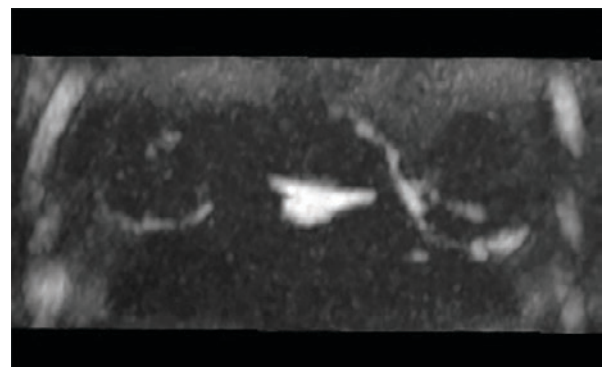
3D T1-weighted image showing the contrast solution within the uterine cavity and around the ovaries after intrauterine administration through the catheter.
